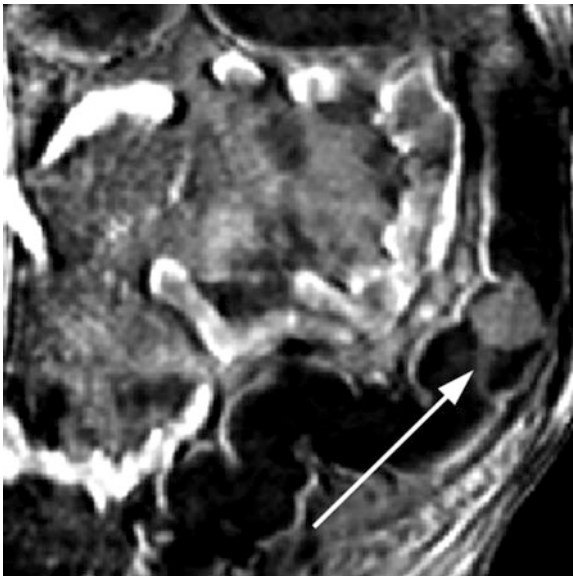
Dark lumen MRC: Coronal T1-weighted SPGR post IV image shows a 2.2 cm pedunculated polyp on a 5 mm stalk within the sigmoid colon (Courtesy of Michael Patrick Achiam, MD, Copenhagen University Hospital Herlev, Herlev, Denmark)
